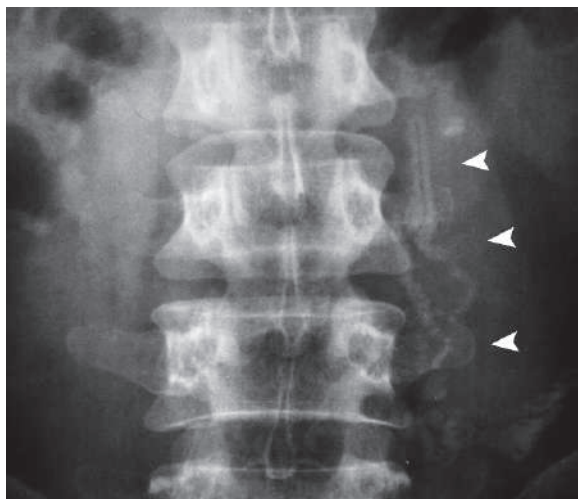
Anteroposterior plain radiograph of the thoracic spine shows linear, beaded, radio-opaque shadow in the left paraspinal region in a patient with dracunculiasis, representing a dead worm (arrowheads)
